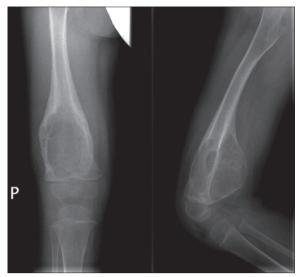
Typical appearance of an ABC on plain radiograph; trauma in anamnesis.
